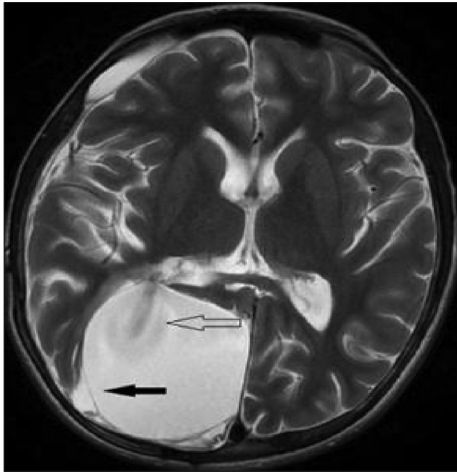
During follow-up, MRI scans showed a porencephalic cyst at the site where the hydatid cyst was extirpated. Interestingly, we noticed a thin outer membrane (black arrow) at the operation site around the porencephalic cavity. The one-way valve mechanism continued to fill the cyst with cerebrospinal fluid. The jet-flow (white arrow) and flow void provided evidence of the one-way filling valve
